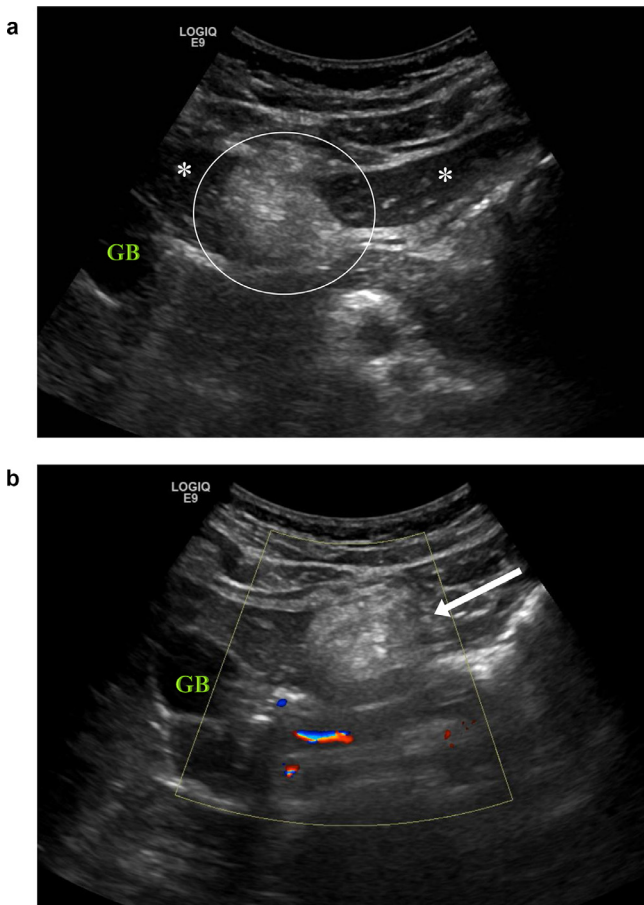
(a) Transverse US demonstrates an ill-defined echogenic fatty mass (circle), in region of the falciform ligament dividing the medial and lateral segments of the left lobe of the liver (asterisks). GB = gallbladder. (b) Transverse US mid abdomen with color Doppler. Image demonstrates a hyperechoic mass (straight arrow) with no internal flow. GB = gallbladder.
